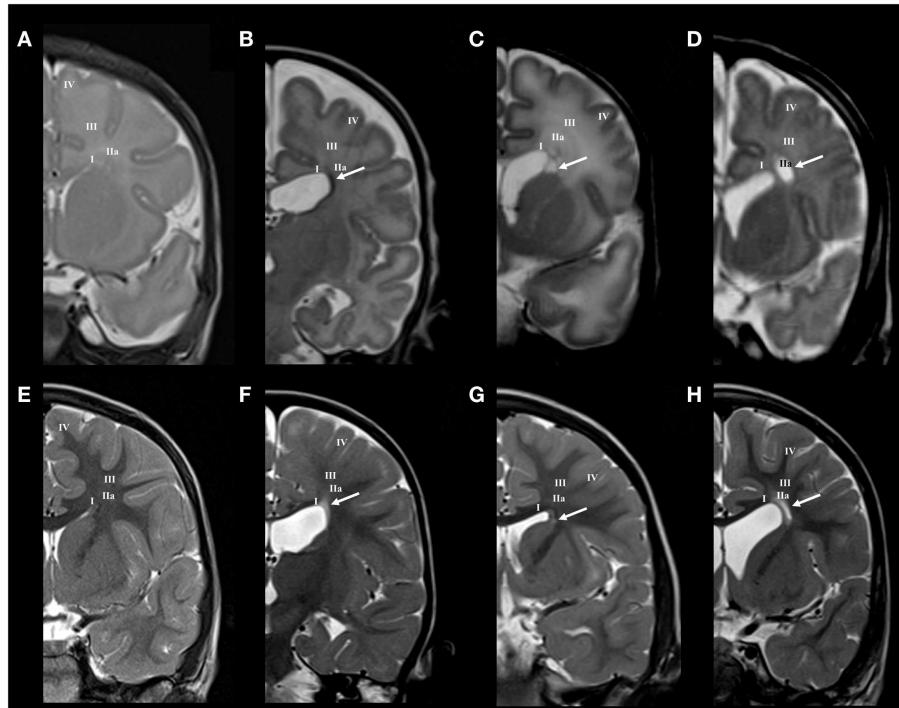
Longitudinal MRI follow-up of perinatal periventricular pathways lesions on coronal T2 images. Normal findings of periventricular white matter at term (A) and at the age of 3 years (E). Early preterm [born at 25 PCW, birth weight (BW) = 800 g, SNAPII = 35, SNAPPEII = 63, Apgar score (AS) = 9/10] with hemorrhagic lesion in area of subcallosal fascicle at term equivalent age [arrow in (B)], which changed to gliotic scar at the age of 2 years [arrow in (F)]. Early preterm [born at 28 PCW, BW = 1080 g, SNAPII = 13, SNAPPPII = 31, AS = 2/4]
